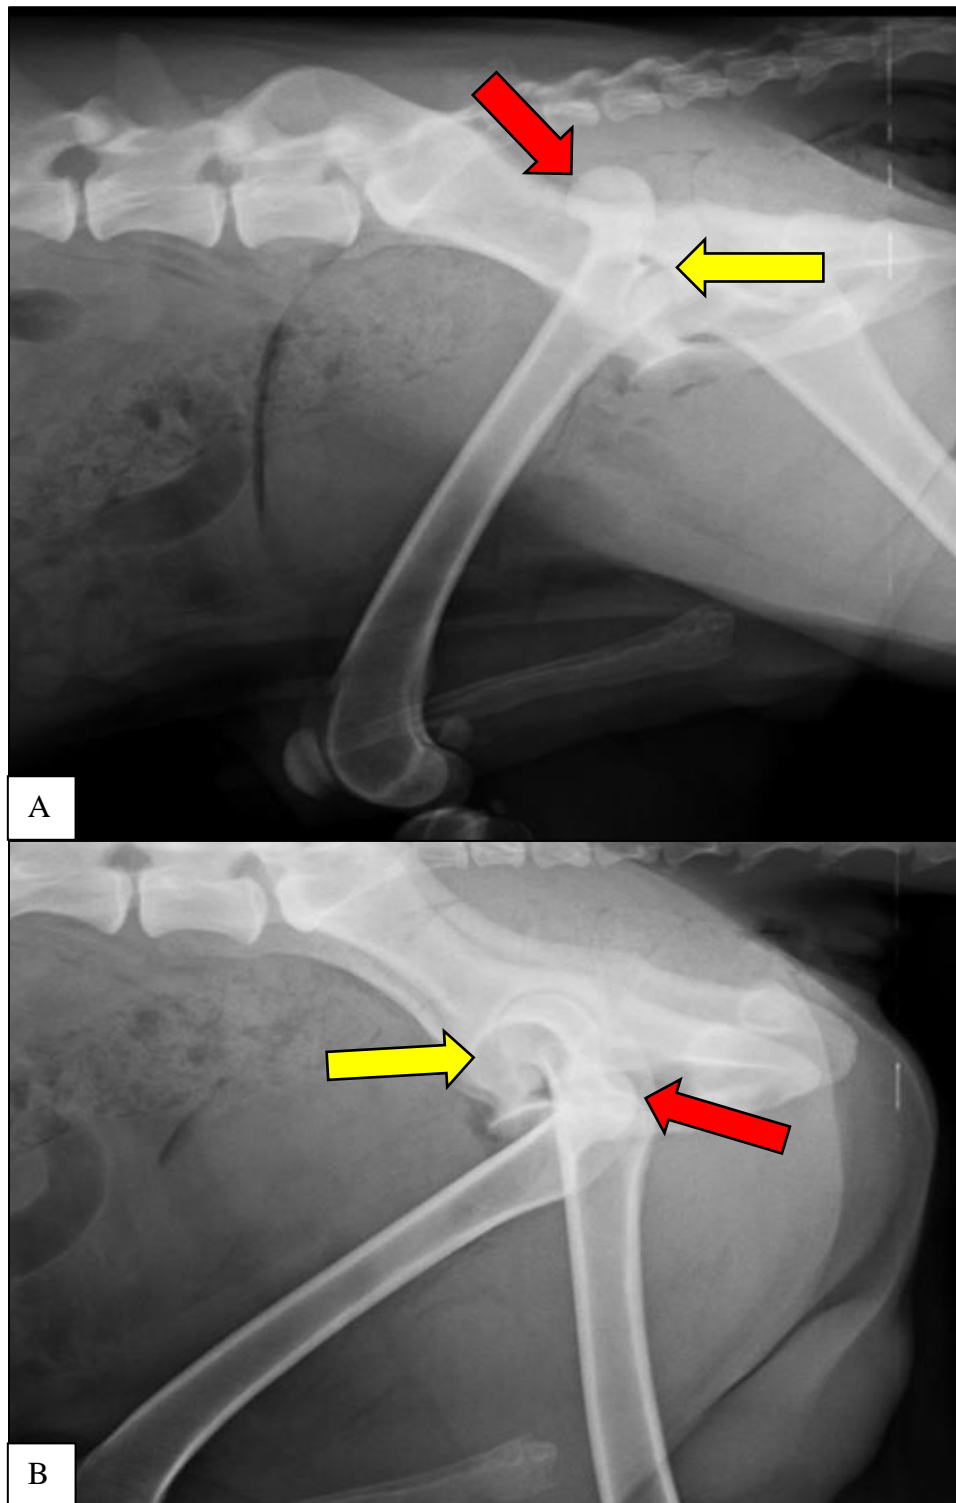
Radiographic images of the lateral projection of the dislocated right hip joint in the craniodorsal direction (A) and caudoventral direction (B). Notice the empty acetabulum (yellow arrow) and the dislocated femur head (red arrow).
